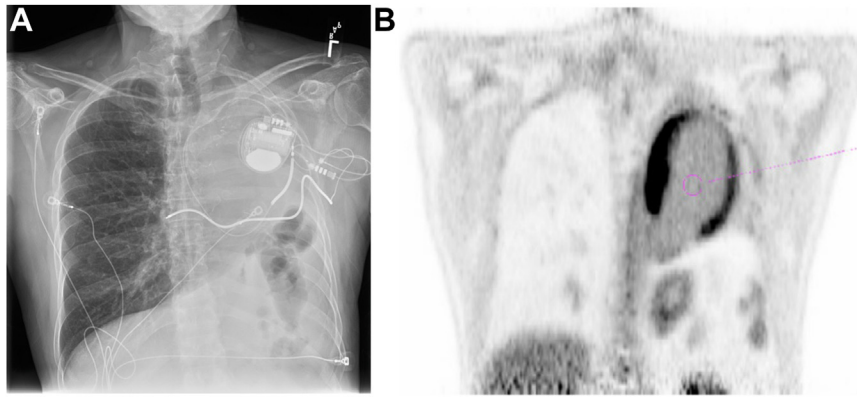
A: Posterior-anterior radiograph of implanted implantable cardioverter-defibrillator in pneumonectomy patient. B: Prior positron emission tomography fludeoxyglucose-18 scan shows cephalad displacement of cardiac apex with left ventricular myocardium uptake.
